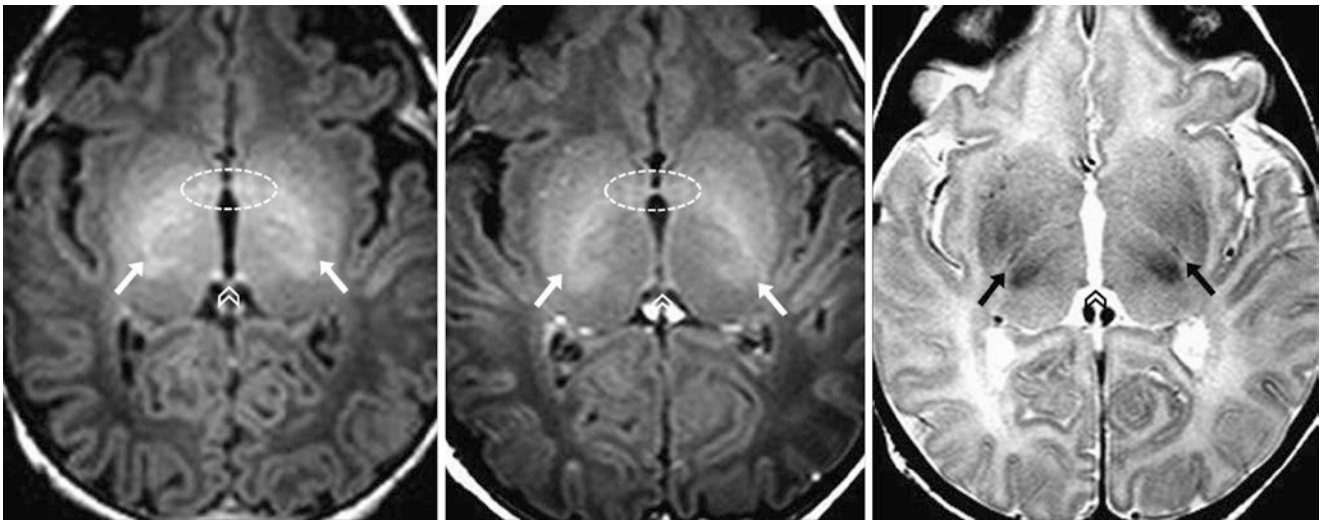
A 6-day-old term neonate had a normal 3T MRI with GE T1WI (*left*), SE T1WI (*middle*), and SE T2WI (*right*). The HC (*chevrons*) and PLIC (*arrows*) are better visualized on GE T1WI, but they appear myelinated on both sequences. On T1WI, the PLIC is a bit
